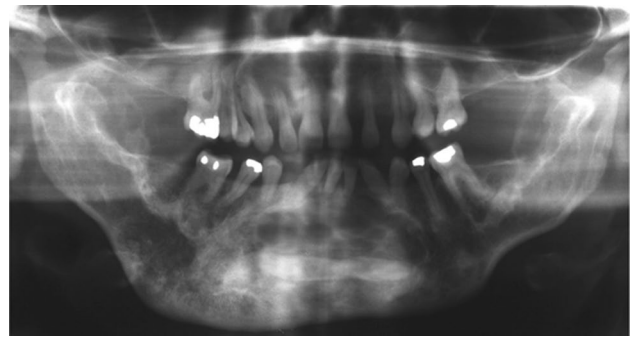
Panoramic radiograph of the mother of the proband (II3) showing an ill-defined, expansile, mixed radiolucent/radiopaque mass extending between first right and left mandibular premolars (teeth #21–28)
